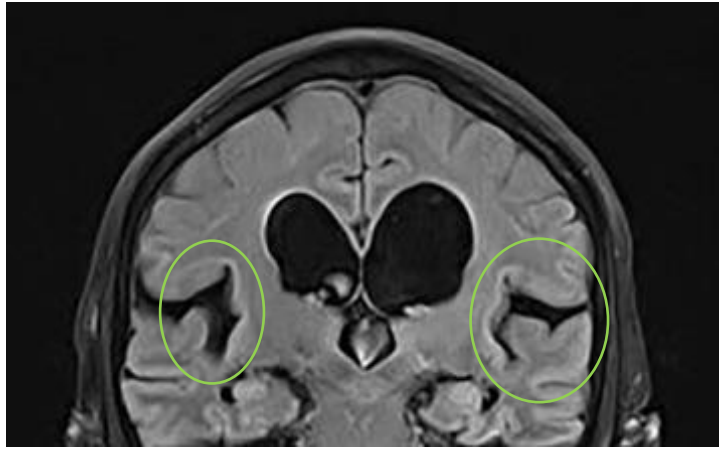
Coronal T2 MRI scan of a normal pressure hydrocephalus patient with dilated Sylvian fissures (Toma, 2018). Copyright 2018 by Elsevier.
